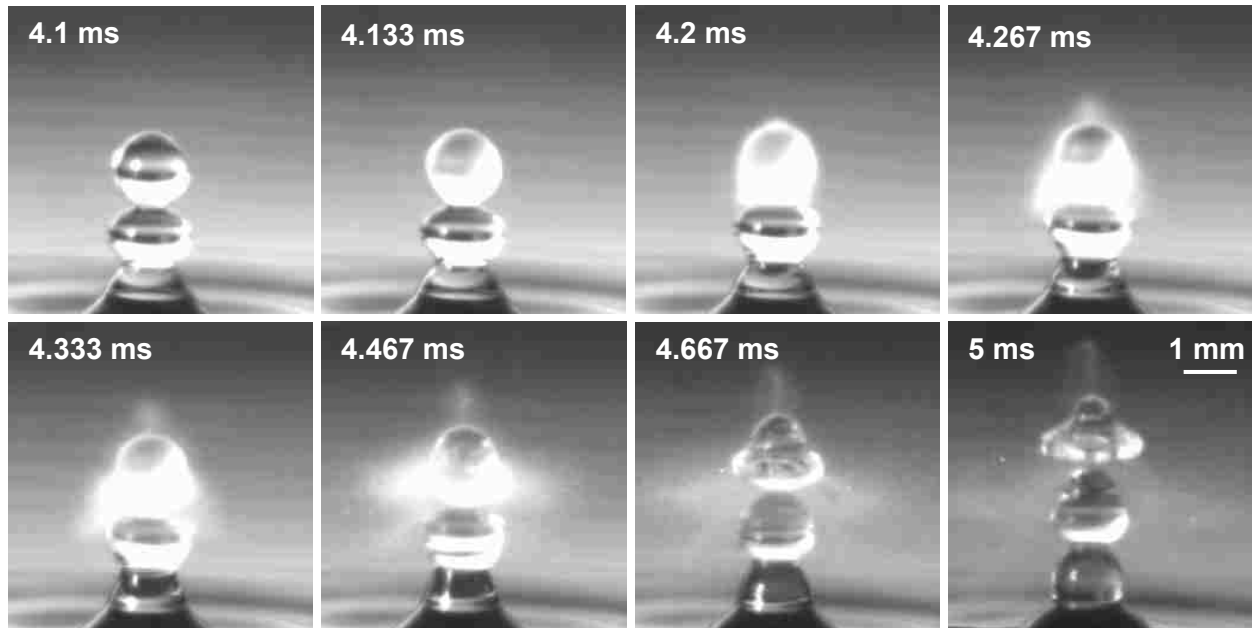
High speed video frames from the water-air interface exposed to 1 MHz focused ultrasound ($p_+ = 3.1$ MPa, $p_- = 2.3$ MPa) and filmed at 30,000 fps. The top water droplet in the first frame is very reflective, yet appears opaque 33 μ s later as shown in the second frame. After the droplet becomes opaque, it begins to emit droplets in the same triangular pattern that was observed in the 2 MHz exposure (figure 4.2(a)). The fine mist of droplets continues to move away from the drop chain in the following frames. By the final frame, the top droplet in the drop chain is completely detached from the rest of the chain and is no longer even remotely spherical in shape. The entire atomization sequence takes place in less than 1 ms. The total ultrasound exposure was 10-ms in duration.
